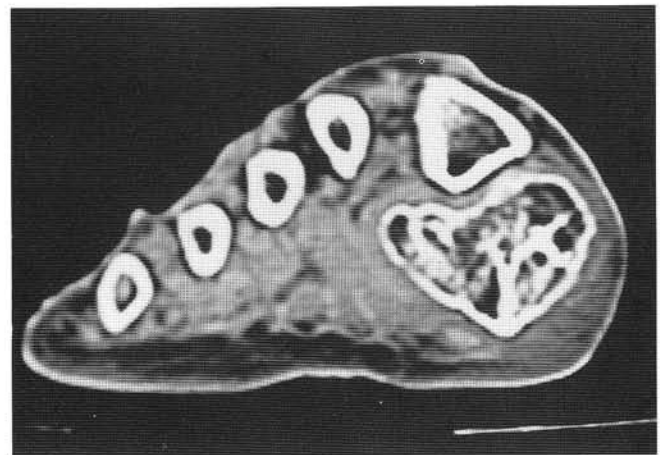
The CT scan shows the mass to be separate from the metatarsal and possess a well-formed peripheral cortex.
